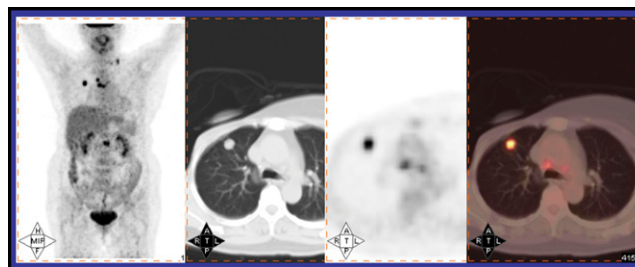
^{18}F -FDG PET/CT imaging (left) as part of treatment management in a patient with breast cancer identified an incidental adenocarcinoma in the right lung (right 3 images).
